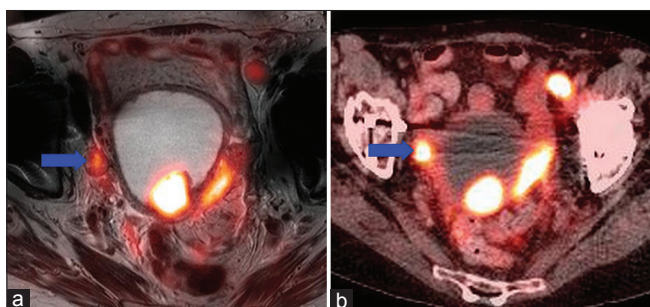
Positron emission tomography/magnetic resonance (a) showing less intense uptake of nodal metastasis (blue arrow) compared to positron emission tomography/computed tomography (b) likely due to errors in attenuation correction resulting from susceptibility artifacts around a hip arthroplasty
